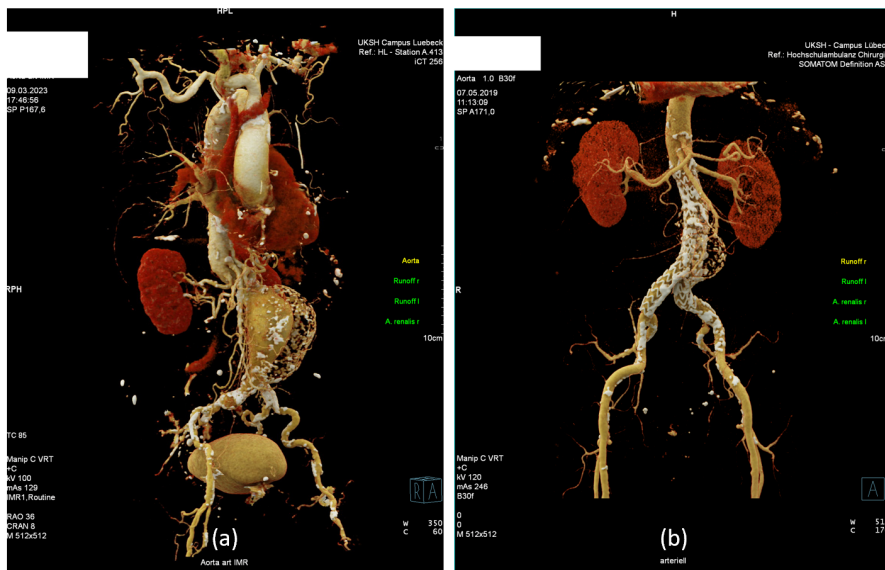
Rendering of CTA data of an AAA (a) before and (b) after EVAR. Images used with permission from Malte Sieren (Department of Radiology and Nuclear Medicine, University Hospital Schleswig-Holstein Campus Lübeck).
